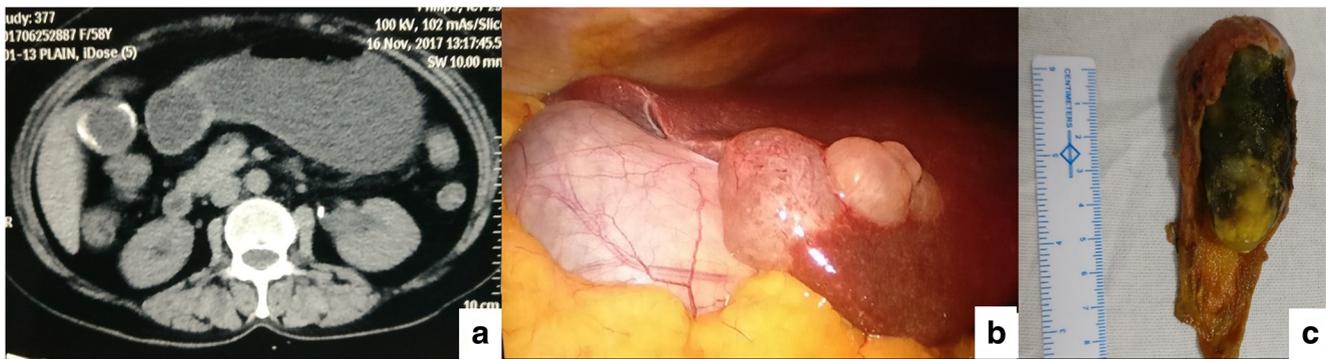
a Plain computed tomography showing calcification appearing to involve the gallbladder wall. No SOL are noted in the adjacent liver. b Intraoperative photograph showing non-contiguous multinodular lesion
